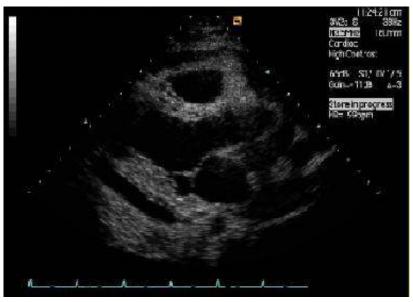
2-D Trans-thoracic echocardiography showing dilated left atrium with significant amount of pericardial effusion surrounding the heart
